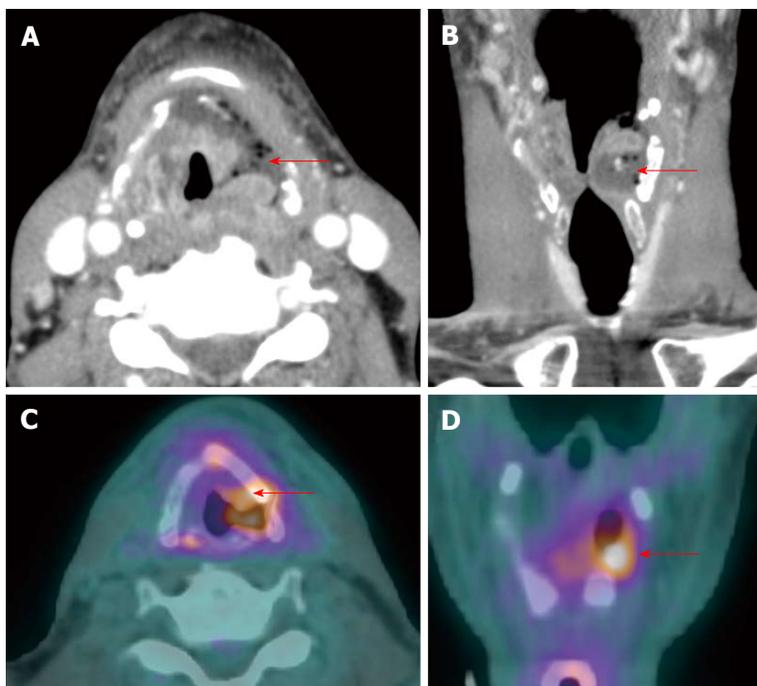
False positive positron emission tomography/computed tomography result due to post treatment infection. A T3N0M0 left supraglottic squamous cell carcinoma showed edema and necrosis at the tumor site (red arrows) on contrast-enhanced computed tomography (CT) (A and B) at 5 wk after chemoradiation and increased uptake on positron emission tomography/CT (PET/CT) (C and D) at 10 wk. The patient had severe throat pain and fever. A residual tumor can not be excluded, therefore endoscopy with biopsy was performed showing radiation-induced inflammation, tumor necrosis and superimposed actinomycosis causing a false positive result on PET/CT. Due to lack of viable tumor, no salvage surgery was performed. The patient was disease free at two-year follow up.
